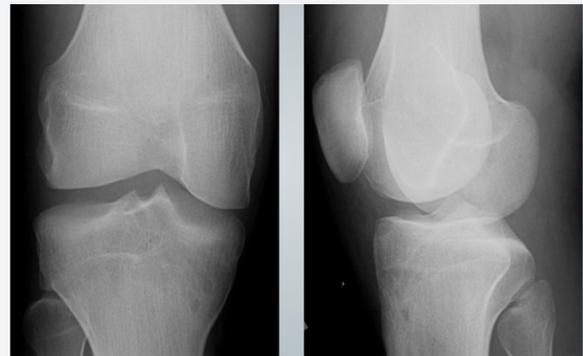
AP and Lat X-rays of the right knee showing the linear translucency of the bone tunnels at the level of the tibial plateau.
